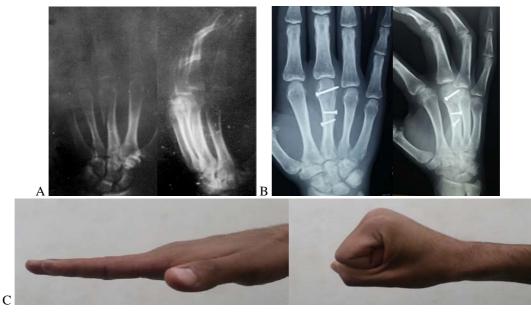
(a) preoperative and (b) six weeks postoperative plain X-ray of third metacarpal fracture with intraarticular extension to metacarpophalangeal joint fixed by three screws (c) six weeks postoperative range of motion
